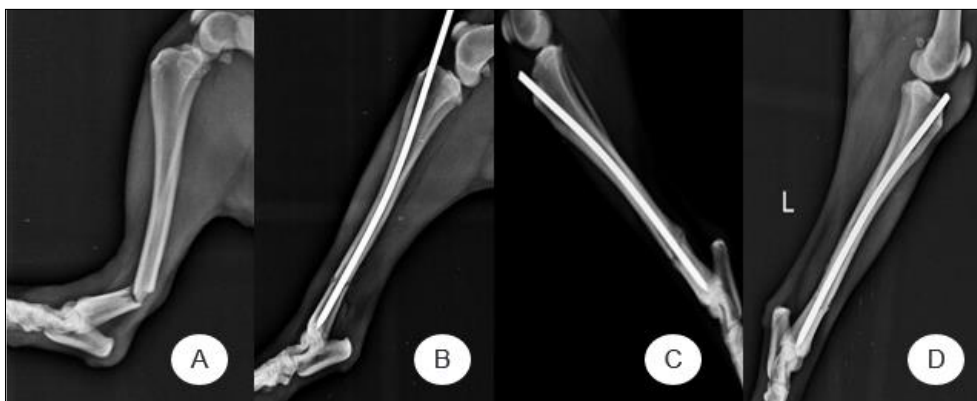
Mediolateral radiographic views of transverse distal diaphyseal fracture of tibia (A) treated with closed method just after surgery (B), 15 (C) and 30 (D) days post surgery.
